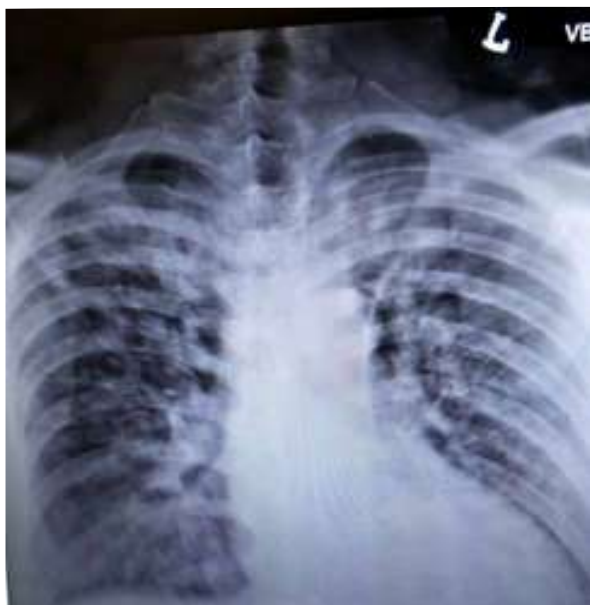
X-ray showing widened mediasfinum
